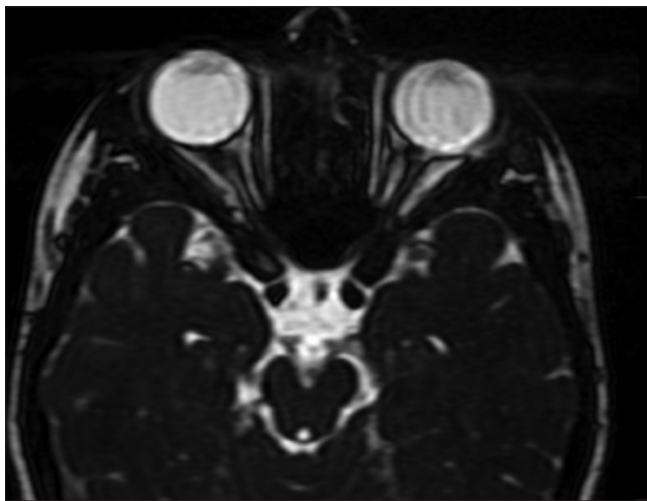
Axial T2 MR image showing bilateral thinned out optic nerves with prominent optic nerve sheath fluid
